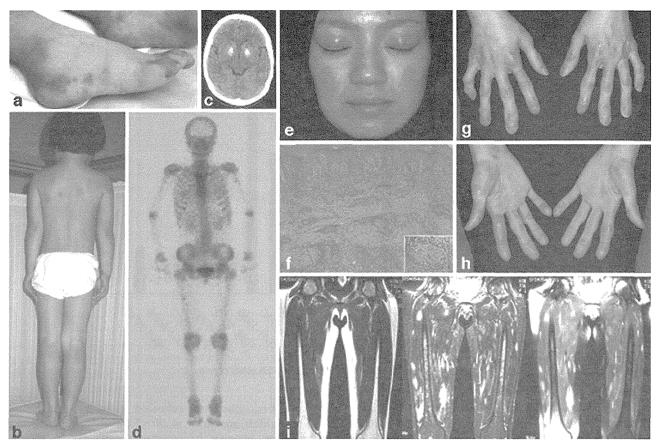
Clinical features of an NNS case. a) Pernio-like purplish rashes on feet at 5 years of age. b) Equinus position caused by myositis in lower extremities. c) Basal ganglia calcification on cranial computed tomography at 24 years of age. d) Technetium uptake in multiple joints shown by bone scintigram. e) Angular facial appearance with emaciation and helliotrope-like periorbital rash at 27 years of age. f) Dense infiltration of inflammatory cells throughout dermis and vasculopathy with endotheial proliferation. g) Long clubbed fingers. h) Nodular erythema-like eruptions on hands and wrists. i) Multiple focal myositis revealed by magnetic resonance imaging. T1, T2, and T1 with gadlinium enhancement, from left to right.
